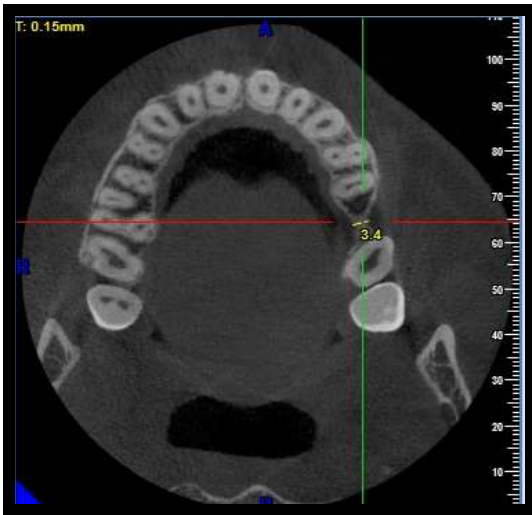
Pretreatment CBCT showing residual bone width of 3.4mm
